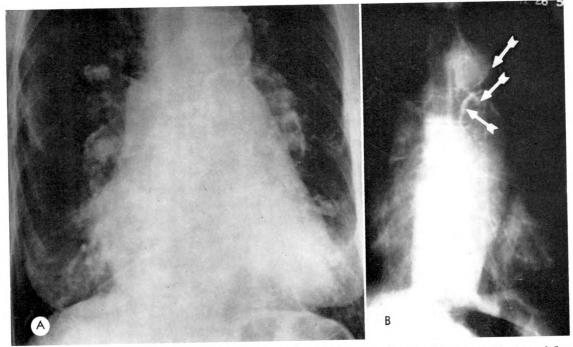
Calcification of the pulmonary artery, ductus, and aortic knob in a 65 year old woman with reversed flow through a patent ductus arteriosus and left ventricular septal defect. (A) Frontal teleroentgenogram showing the enlarged heart, pulmonary artery, and plethoric lungs. (B) Overpenetrated frontal roentgenogram of the chest shows to advantage the calcification of the aortic knob (upper arrow), and pulmonary artery (lower arrows). (Reproduced with permission of the Am. J. Med.⁸)
